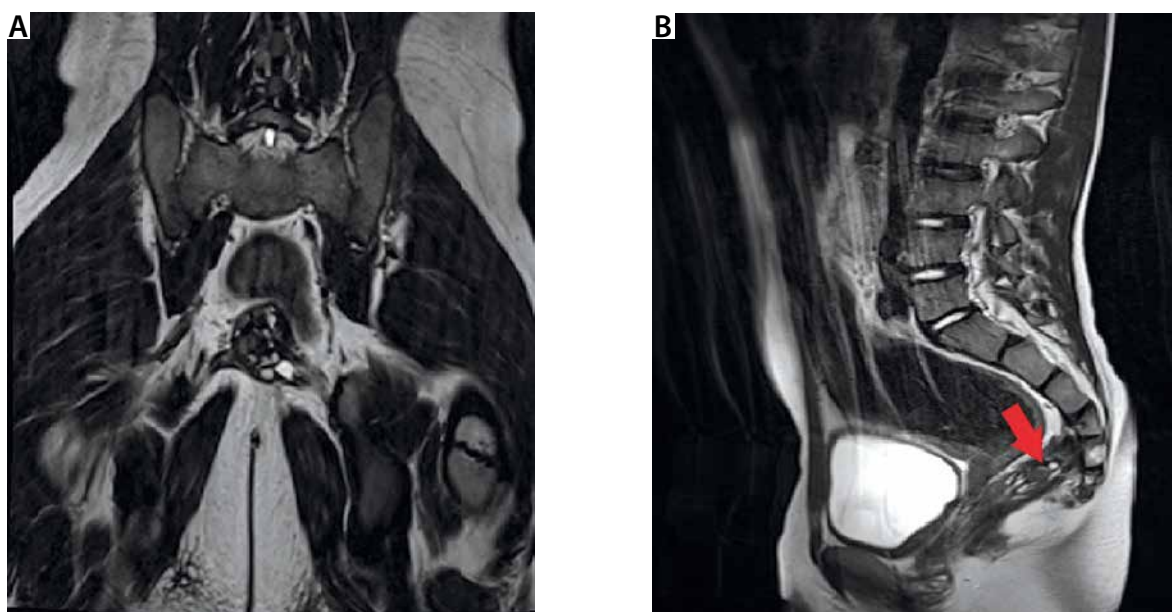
Magnetic resonance imaging scan showing a solid-cystic mass (indicated with an arrow) in the retrorectal space
